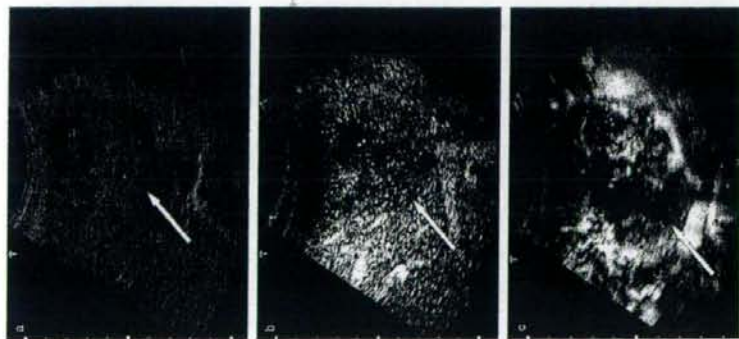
A 69-year-old woman with a 30-mm-diameter, poorly-differentiated hepatocellular carcinoma (HCC) in the left lobe of the liver. (a) Baseline ultrasound image shows a HCC (arrow) with insular pattern appearance in the left hepatic lobe. (b) Conventional Doppler image obtained during the portal venous phase—that is, 45 s after injection of the microbubble contrast agent—shows HCC (arrow) with heterogeneous enhancement. An avascular area, which is believed to be a necrotic region, is also noted in the tumor. (c) Microflow image obtained during the portal venous phase—that is, 53 s after injection of the microbubble contrast agent—shows tumoral blood vessels clearly. However, they are sparser than in moderately-differentiated HCC. Tapering and interruption of the vessels may be noted. Properties are characteristic of the dead wood pattern.
